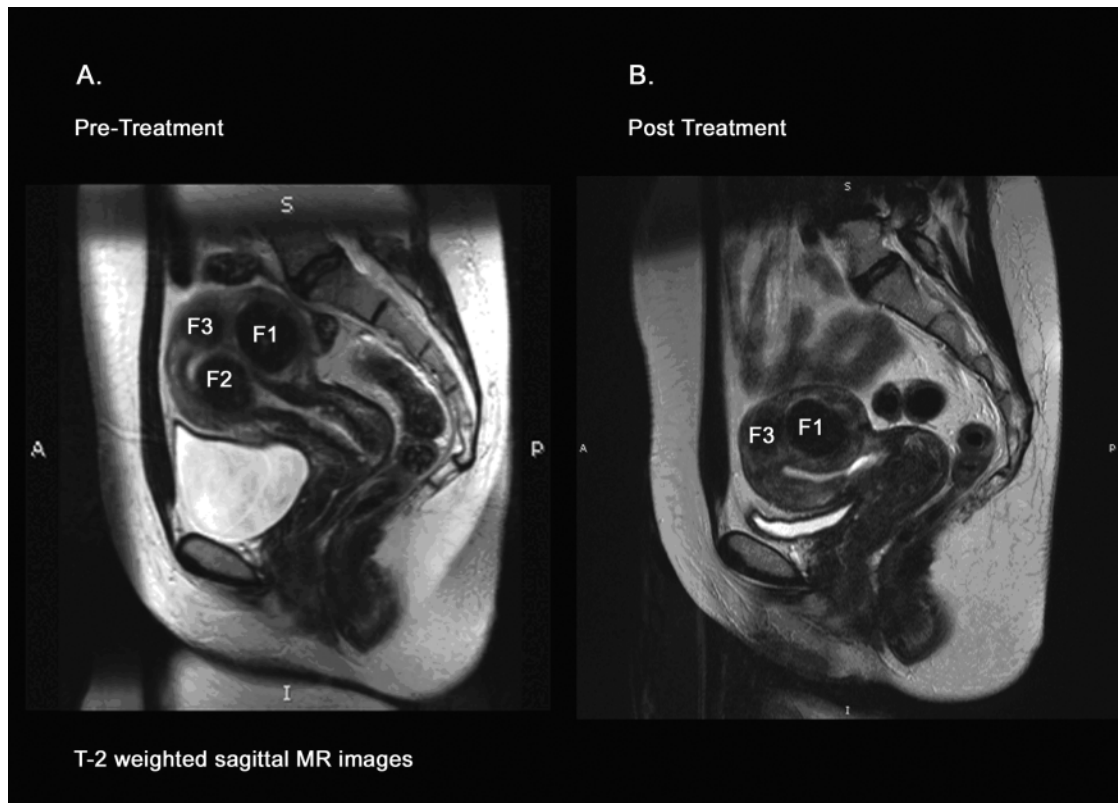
(A) Pretreatment T2-weighted midline, sagittal magnetic resonance image showing the uterus and one 4 cm (F1) and two 3 cm (F2, F3) fibroids. (B) Eight months after temporary uterine artery occlusion, demonstrating uterine volume reduction (44%) and reductions in the fibroids: F1 (71%), F2 (100%; no longer identified), F3 (84%). 740 × 529 mm (72 × 72 d.p.i.).
